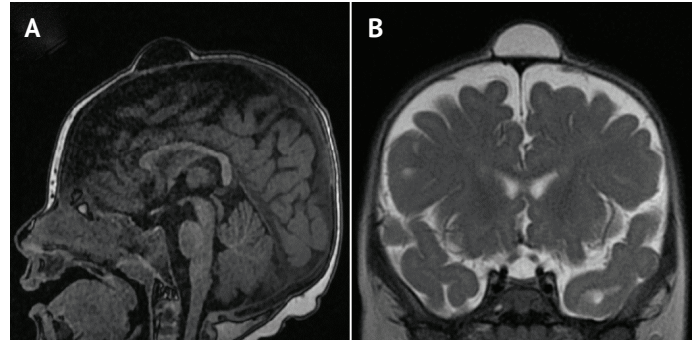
Magnetic resonance images of the cyst. (A) is sagittal view of T1W and (B) is coronal view of T2W images.
